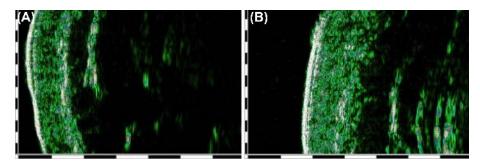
The results of the ultrasound skin examination before (A) and on 30th days (B) after the laser therapy: increase of dermis thickness and density; increase of SMAS thickness and density.
